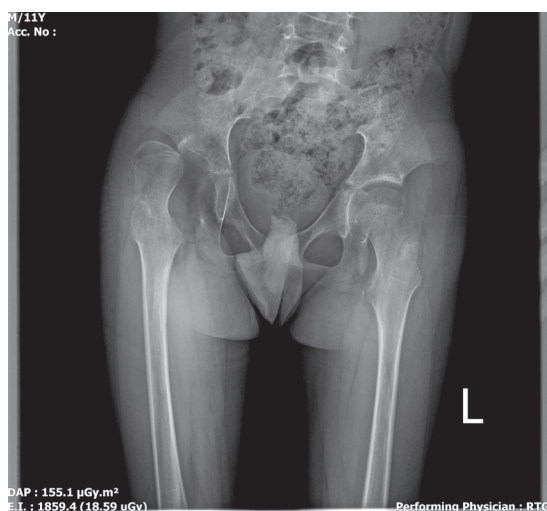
Preoperative radiograph of the pelvis showing right hip dislocation with a very deficient acetabulum.
